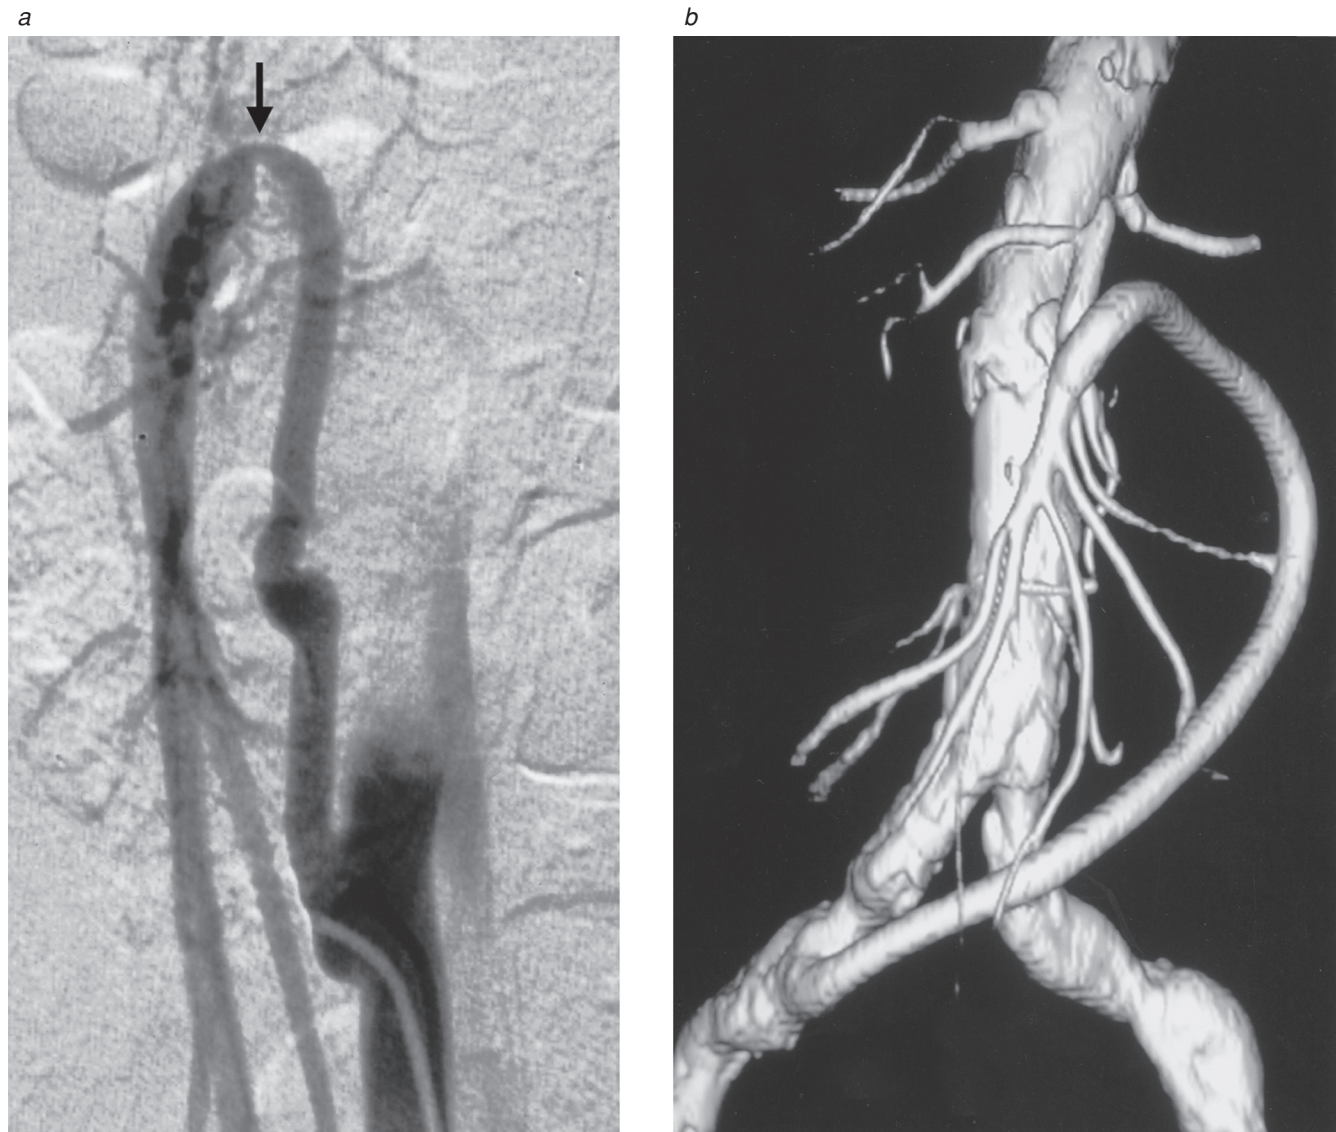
Routine postoperative imaging is performed to confirm technical success after revascularization. (a) A postoperative arteriogram shows a iliac artery–superior mesenteric artery (SMA) saphenous vein graft with a kink (arrow). This problem was asymptomatic and was corrected by reoperation on postoperative day 5. (b) A postoperative computed tomographic arteriogram shows a retrograde iliac artery–SMA prosthetic graft. C (hook) configuration of distal anastomosis provides antegrade flow into the SMA.
